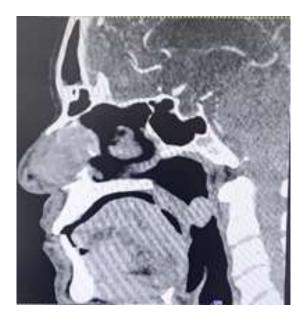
CT image (sagittal view) showing the location of lesion.
